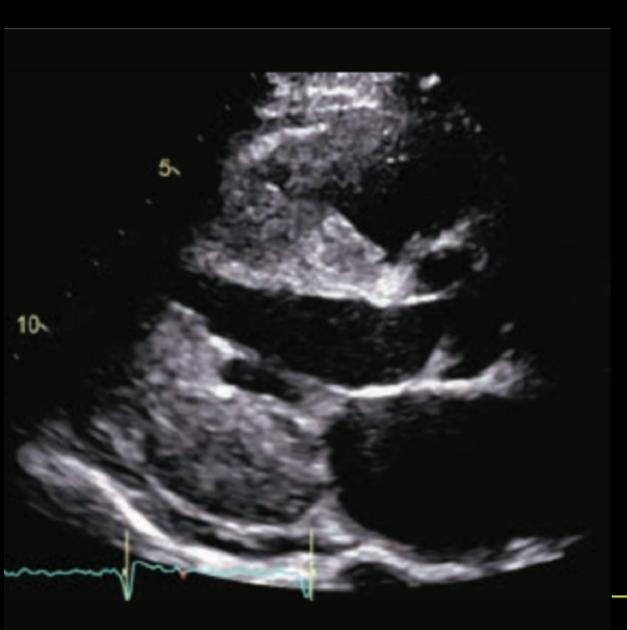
In the parasternal long-axis view, left ventricular wall hypertrophy is evident. Specifically, the basal septum exhibits significant thickening, measuring 22 mm (indicated by the yellow line), while the posterior wall measures 18 mm (also marked by the yellow line). Additionally, the intraventricular septum appears speckled and hyperechoic. Notably, pericardial effusion is observed behind the posterior left ventricular wall (yellow arrow). Ao, aorta; LV, Left Ventricle; RV, Right
